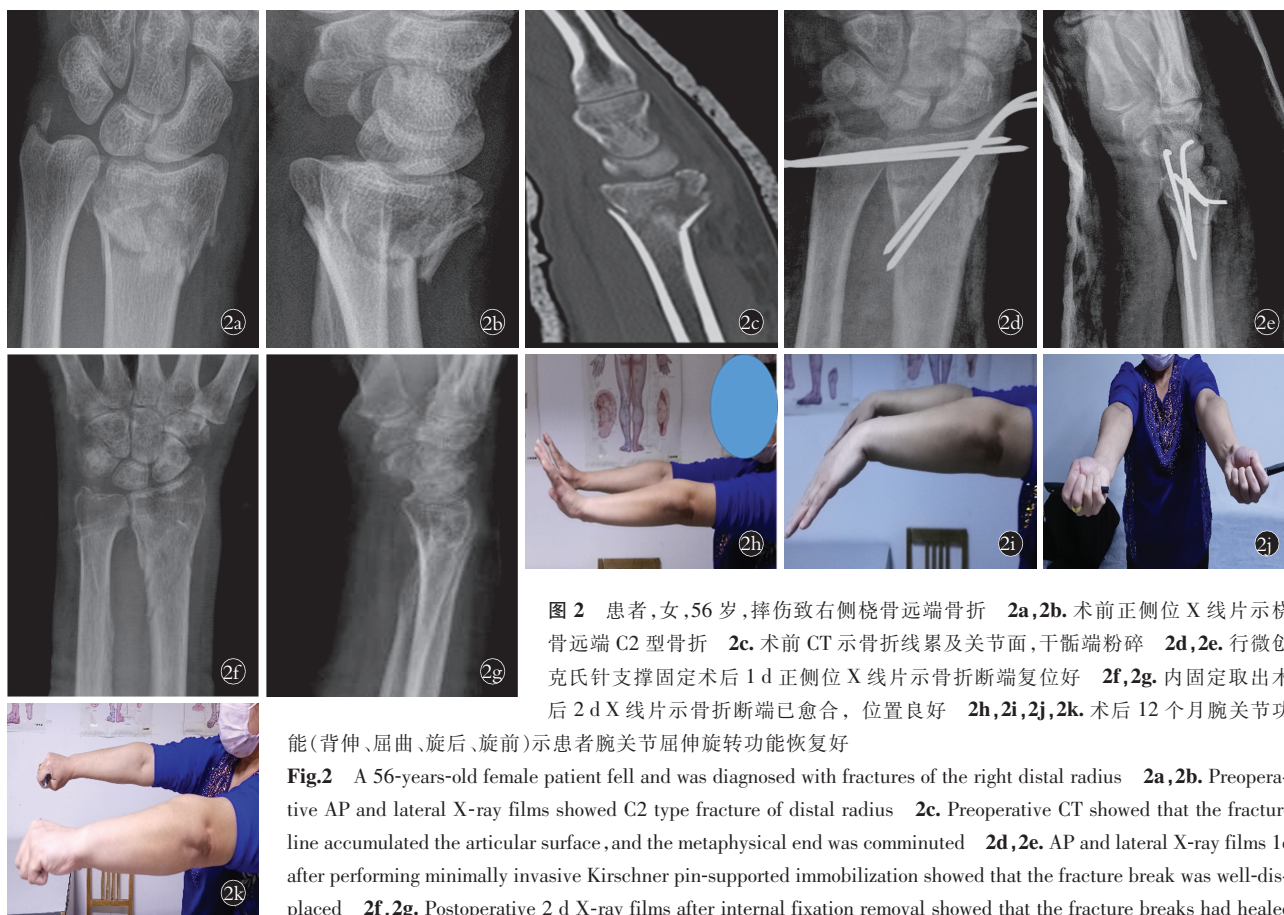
患者,女,56 岁,摔伤致右侧桡骨远端骨折 2a,2b. 术前正侧位 X 线片示桡骨远端 C2 型骨折 2c. 术前 CT 示骨折线累及关节面,干骺端粉碎 2d,2e. 行微创克氏针支撑固定术后 1 d 正侧位 X 线片示骨折断端复位好 2f,2g. 内固定取出术后 2 d X 线片示骨折断端已愈合,位置良好 2h,2i,2j,2k. 术后 12 个月腕关节功能(背伸、屈曲、旋后、旋前)示患者腕关节屈伸旋转功能恢复好
